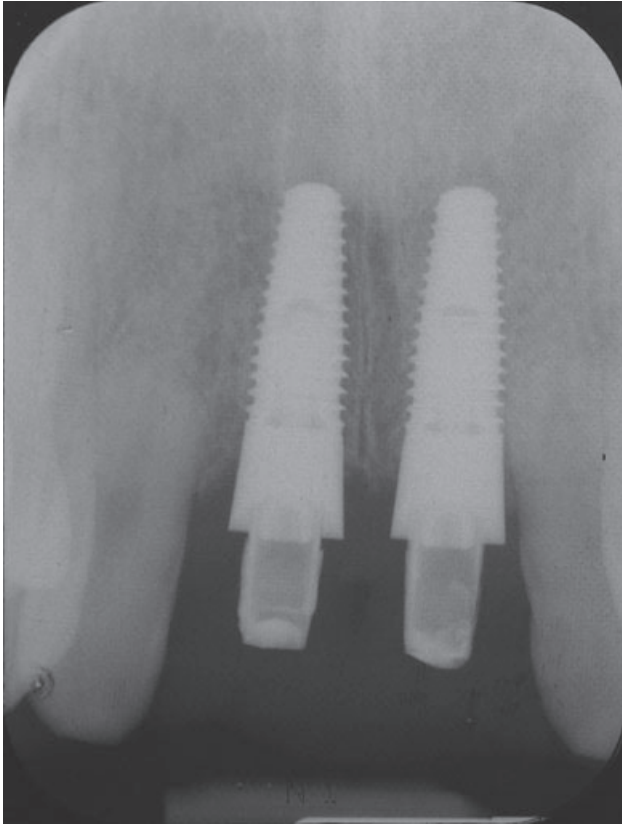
Radiographic view at 3 months postsurgery.
